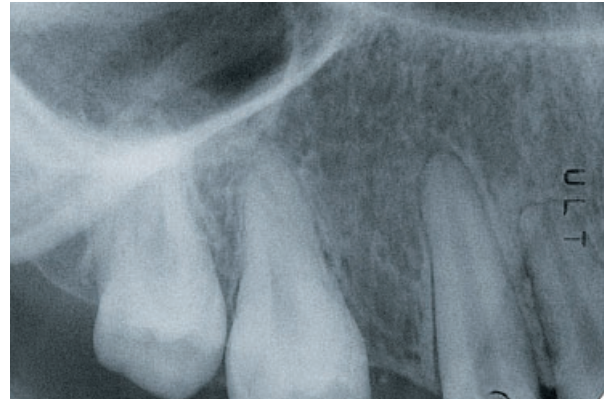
The corresponding radiograph underlines the need for additional orthodontic therapy prior to the insertion of an implant in order to optimize the gap width and the inter-radicular distance.
